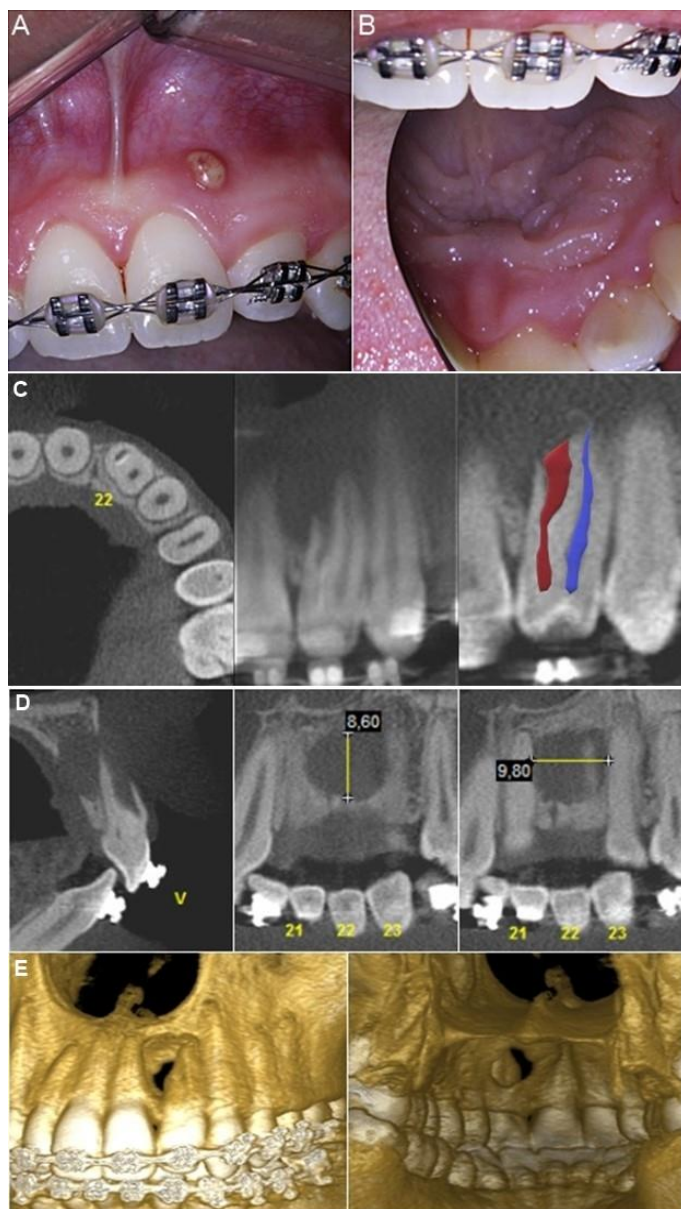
A,B) Clinical view of the tooth displaying the sinus tract; C) The axial and coronal views of CBCT confirm the diagnosis of type III dens invaginatus. In red it can be identified the invagination and in blue, the main canal; D) The extension of the peri-radicular lesion can be demonstrated in the sagittal and coronal views of the CBCT; E) A 3D reconstruction demonstrates the discontinuity of buccal and palatal cortical bone affected.
